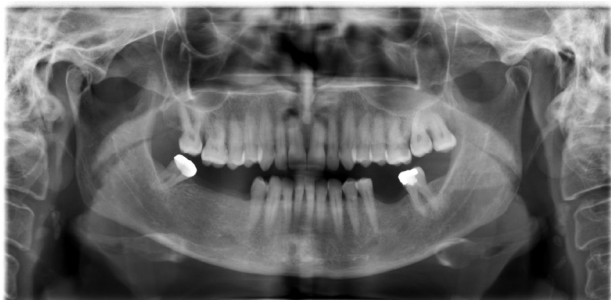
Panoramic radiograph shows bifid mandibular condyle in the both side.
